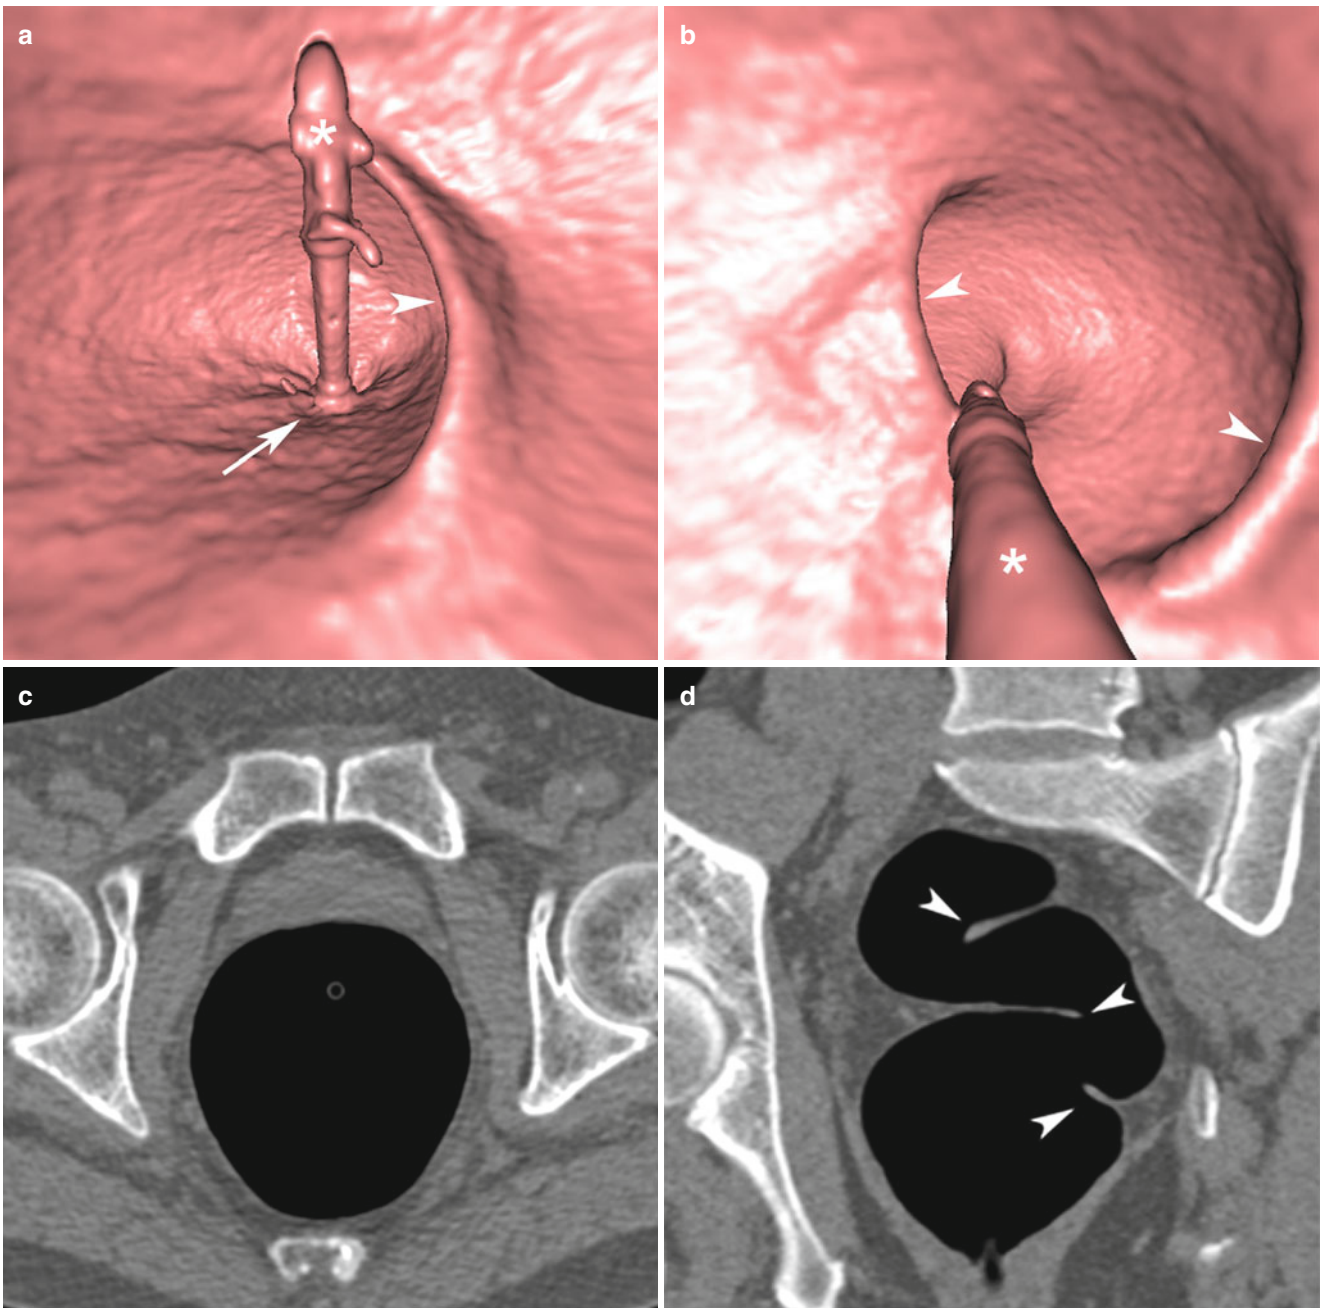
(a) Antegrade endoluminal 3D view shows small radiating folds (*arrow*) at the anorectal junction caused by contraction of the anal sphincter muscles. Distal transverse rectal fold (*arrowhead*) and rectal tube (*). (b) Retrograde endoluminal 3D view showing two transverse rectal folds (*arrowheads*) and the rectal tube (*). (c) Axial 2D CT image
